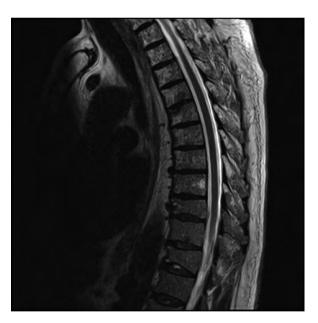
Sagittal magnetic resonance imaging with multiple bone osteolytic lesions of the cervical and thoracic spine
